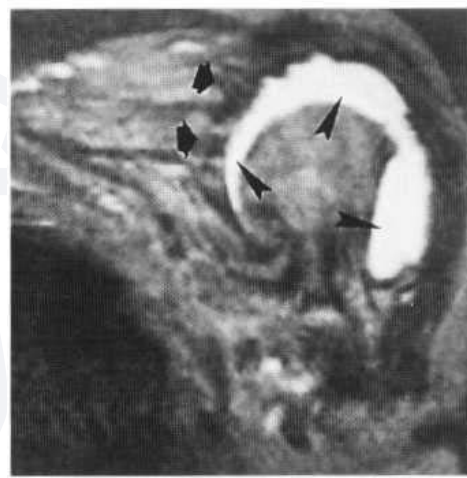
Rotator cuff tear. (A) Arthrography is performed by injecting contrast medium, with or without air, into the shoulder joint. Leakage of contrast into the subdeltoid bursa (arrows) indicates a rupture of the rotator cuff which normally separates the bursa from the joint. (B) MRI demonstrates a large joint effusion, shown as high signal on this FLASH image. The effusion, which shows markedly increased signal intensity on this sequence, has tracked into the subdeltoid bursa (arrowheads), indicating rotator cuff rupture. In this case the subscapularis is seen to be retracted, with an irregular lateral margin (large arrows).
